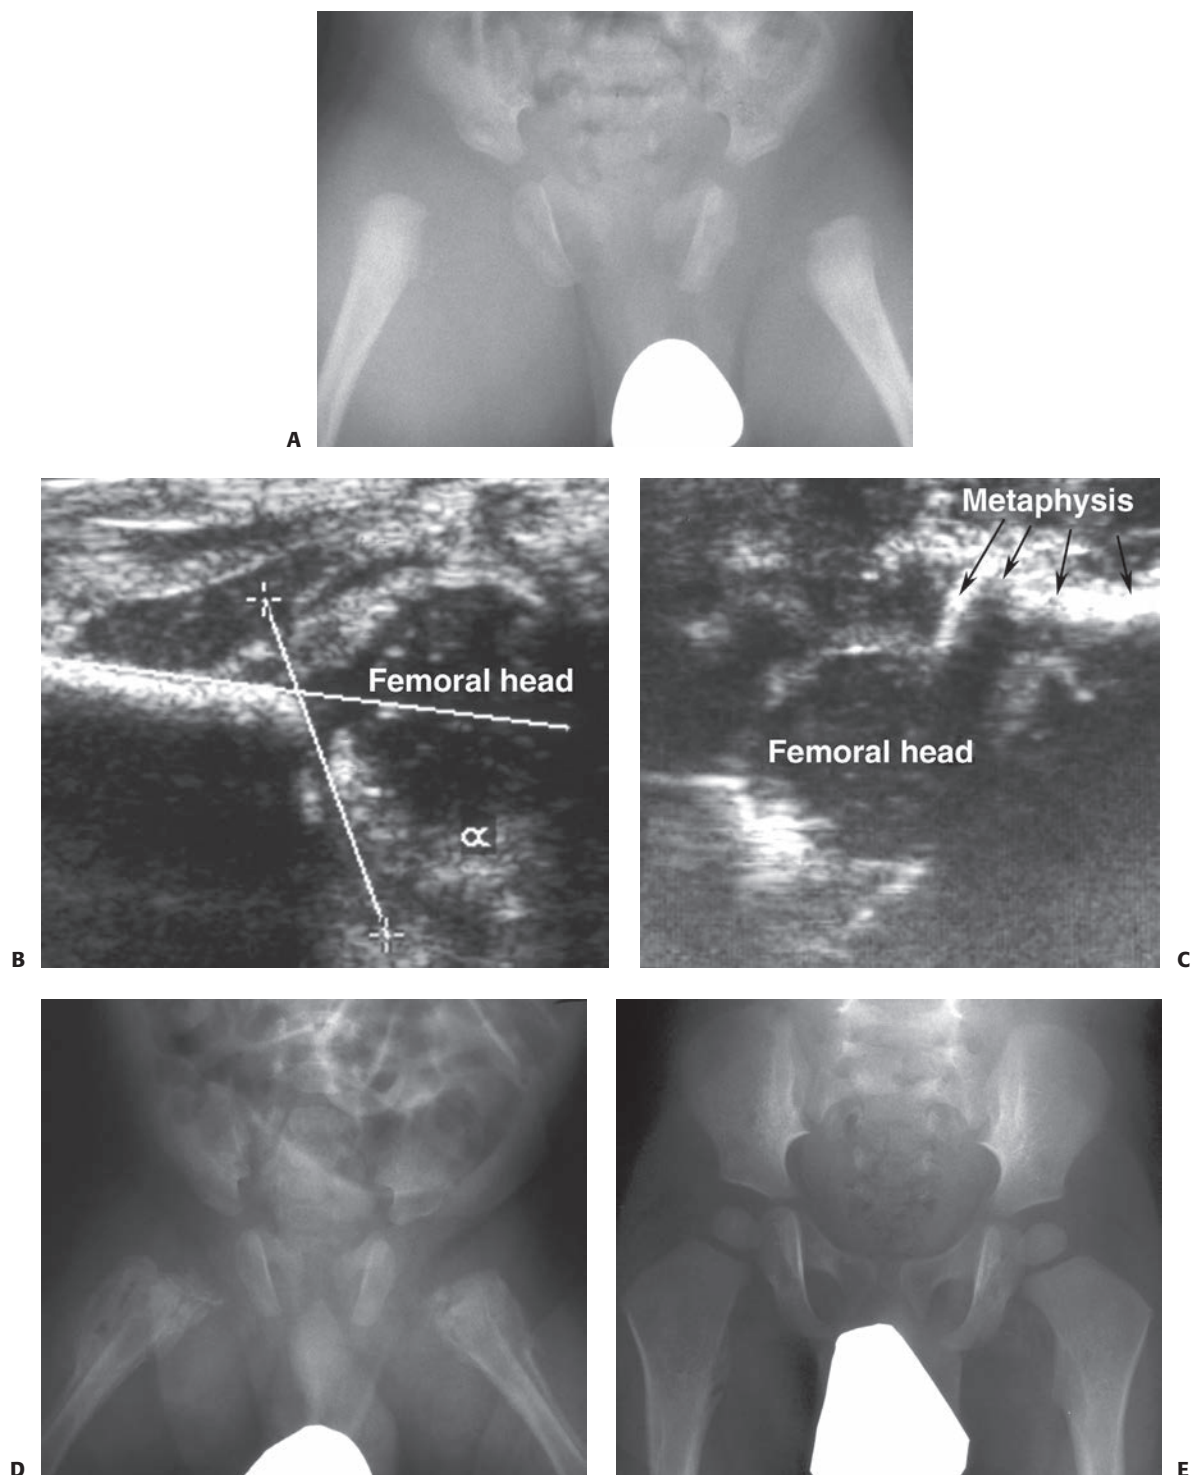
Ultrasonography can be useful as a noninvasive investigation confirming intra-articular effusion or epiphyseal separation, particularly in infants. A: Anteroposterior radiograph of a 2-month-old infant with bilateral hip pain and generalized irritability. Septic arthritis is included in the differential diagnosis. B: Ultrasonographic image of the right hip demonstrates a femoral head contained in the acetabulum, without significant hip effusion. C: This ultrasonographic image demonstrates separation of the proximal epiphysis from the femoral metaphysis. The diagnosis is nonaccidental trauma. D: One month later, radiograph demonstrates extensive periosteal reaction bilaterally. E: At 18 months of age, radiograph demonstrates remarkable remodeling, without evidence of physeal growth disturbance or epiphyseal abnormality.
